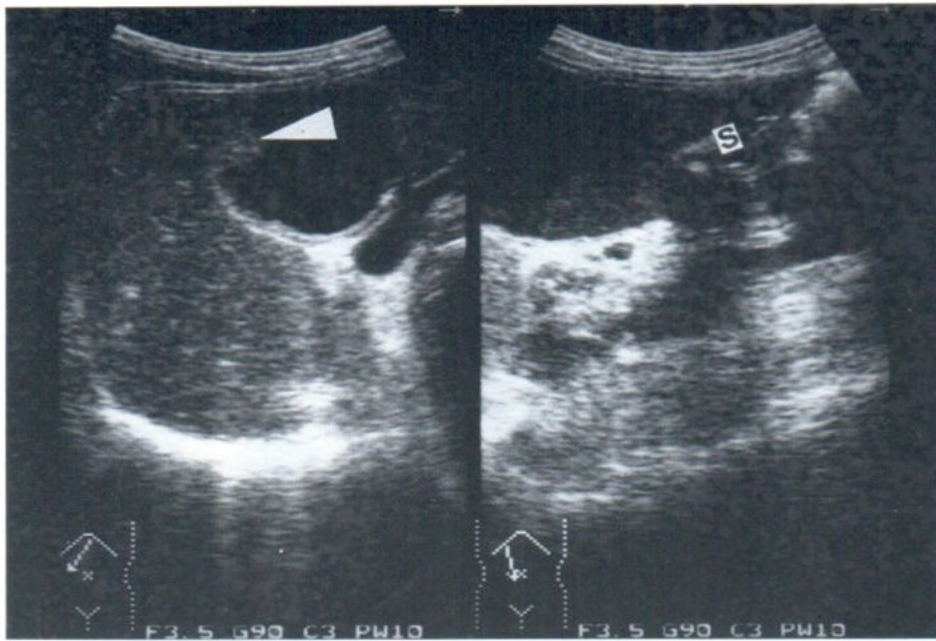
Papillary adenocarcinoma : Longitudinal sonogram of female 72 years old showed small hyperechoic mass (arrow) in gall bladder wall with small gallstone(S).
